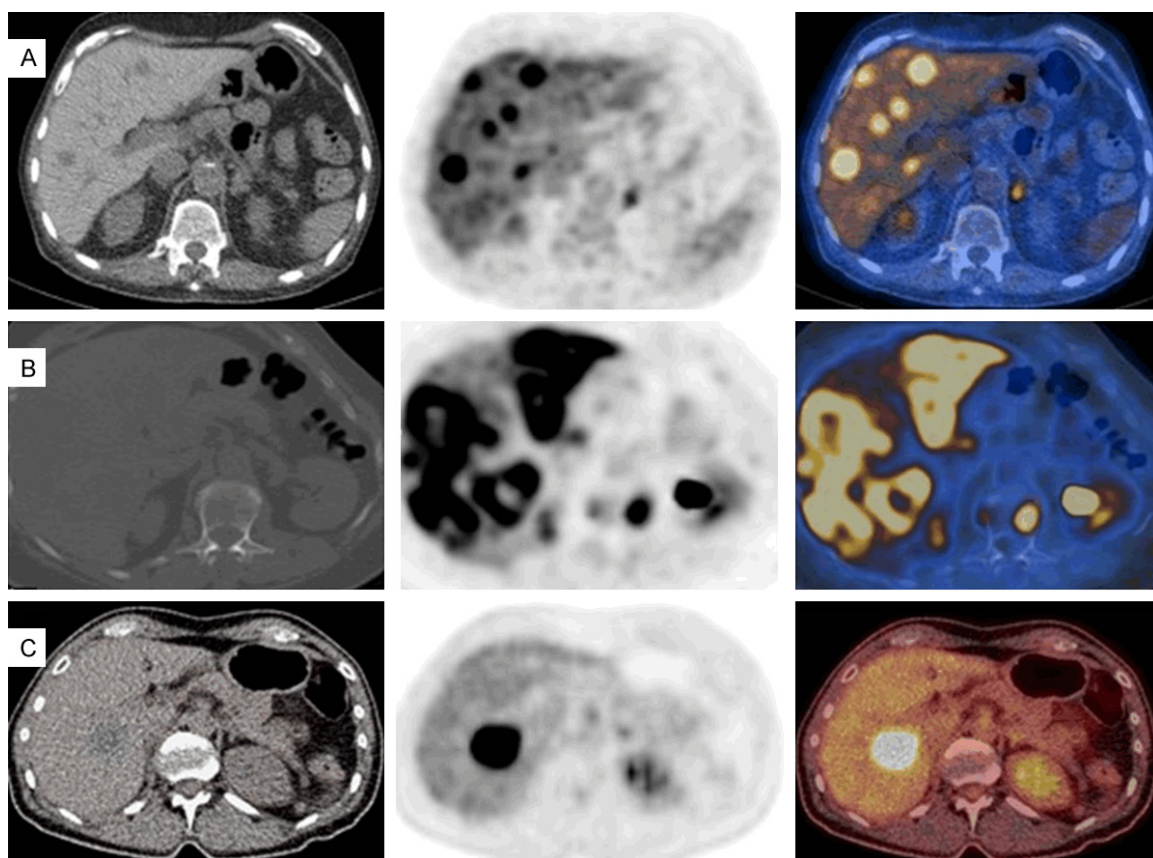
FDG PET/CT images of liver metastases from various tumors (body MIP images in anterior view and selected transaxial PET/CT fusion images of the liver). A. Poorly-differentiated neuroendocrine breast tumor in a male with multiple foci of metastases in the liver (SUVmax: 10.1). B. Invasive ductal breast carcinoma case with diffusely (heterogeneous) increased uptake in the liver (SUVmax: 16.2). C. Non-small cell lung cancer case with a large focal hypermetabolic liver metastasis (SUVmax 12.7).
